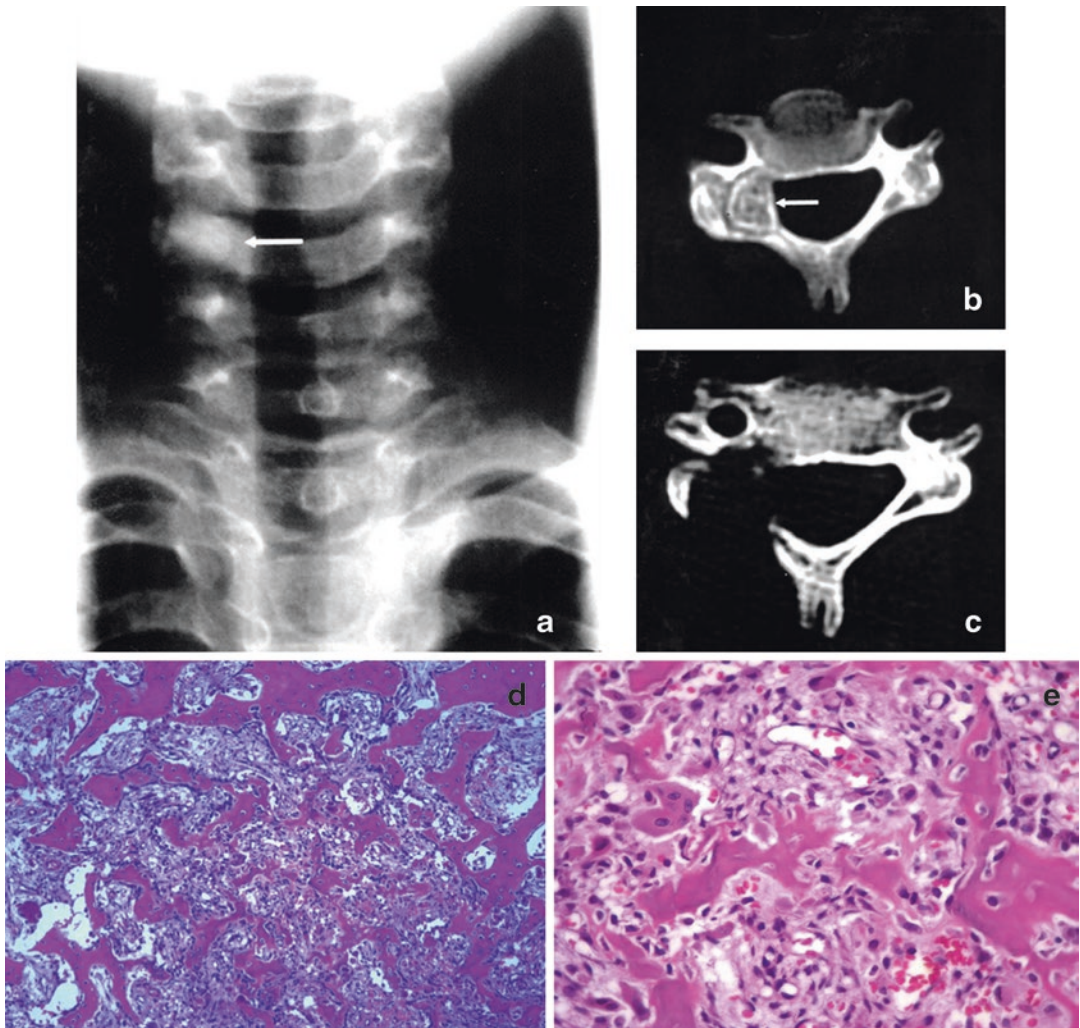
(a–e) Osteoid osteoma of right C5 posterior elements (lamina-lateral mass junction). (a) AP X-ray. (b, c) Axial CT images before and after resection of the lesion.
